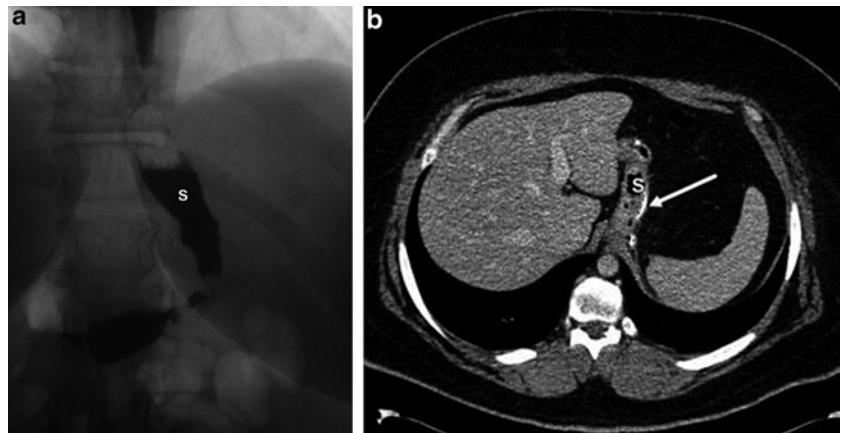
An upper gastrointestinal contrast radiograph showing proximal gastric leak. A cavity is observed adjacent to the stomach (white arrow). Reproduced with permission from *OBES SURG 2011*; 21:1232-1250. Gastric Leak After Sleeve Gastrectomy: Analysis of Its Management.
